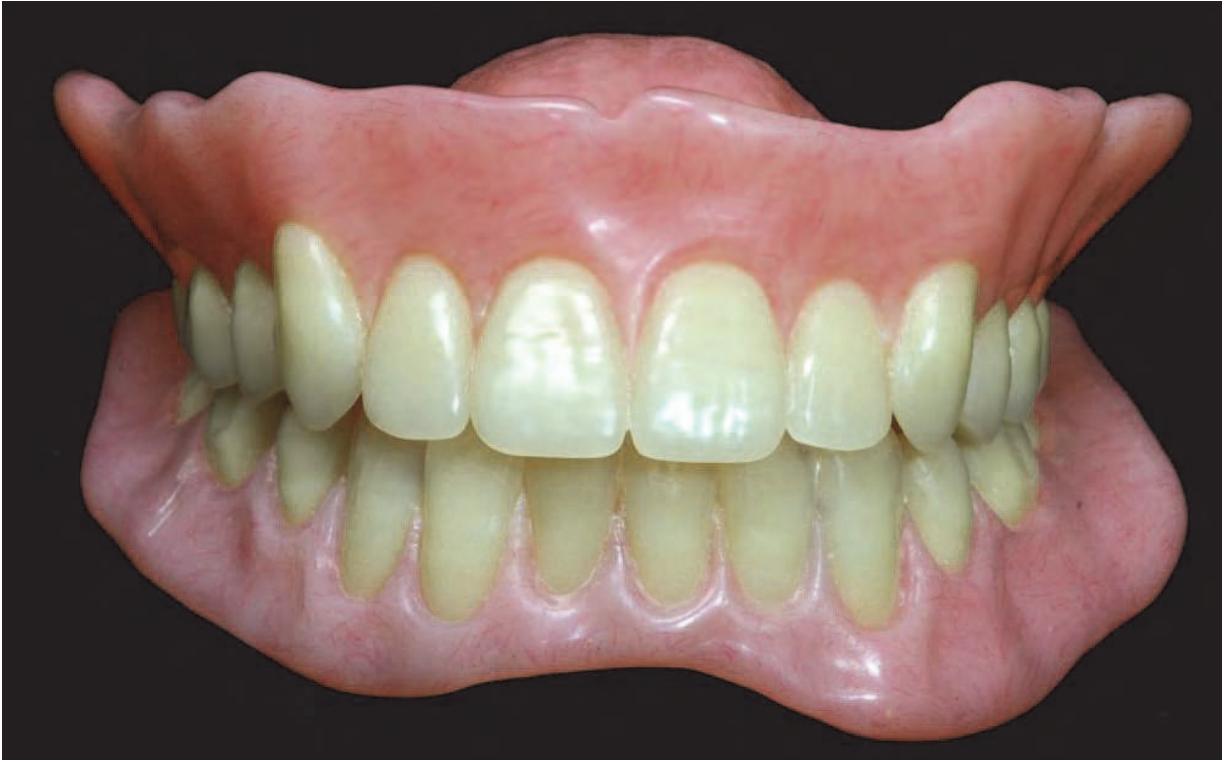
Implant diagnostic dentures to serve as radiographic template for implant planning and surgical guide fabrication.
